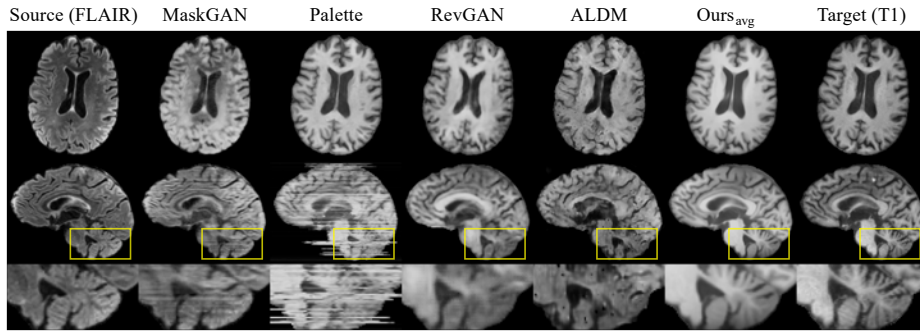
Qualitative comparison with baselines (FLAIR→T1)
